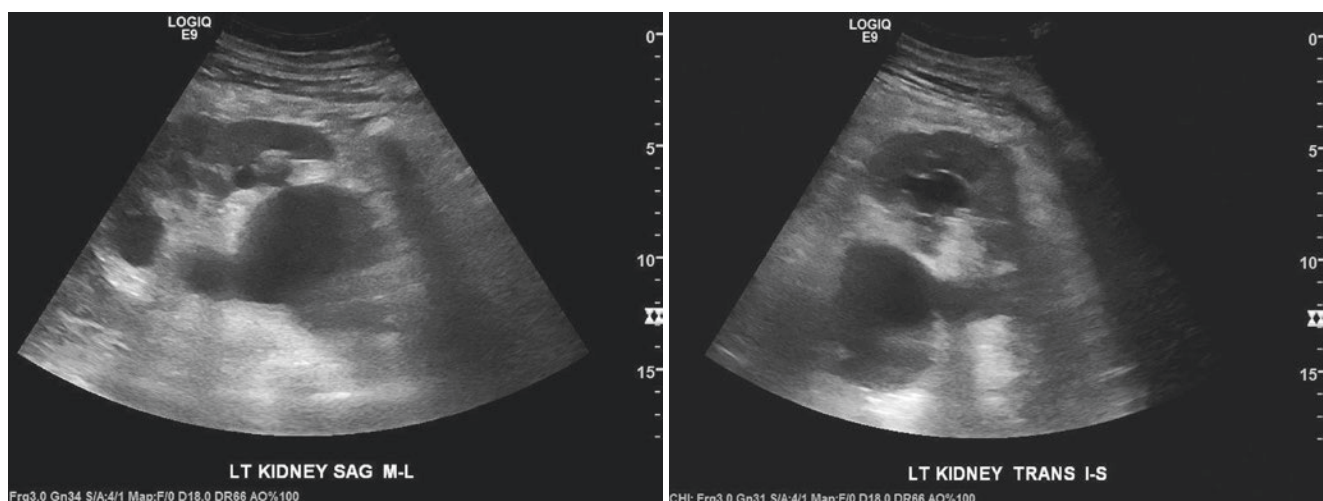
Ultrasound images showing massive dilation of the renal pelvis and collecting system (hydronephrosis) due to ureteral obstruction
